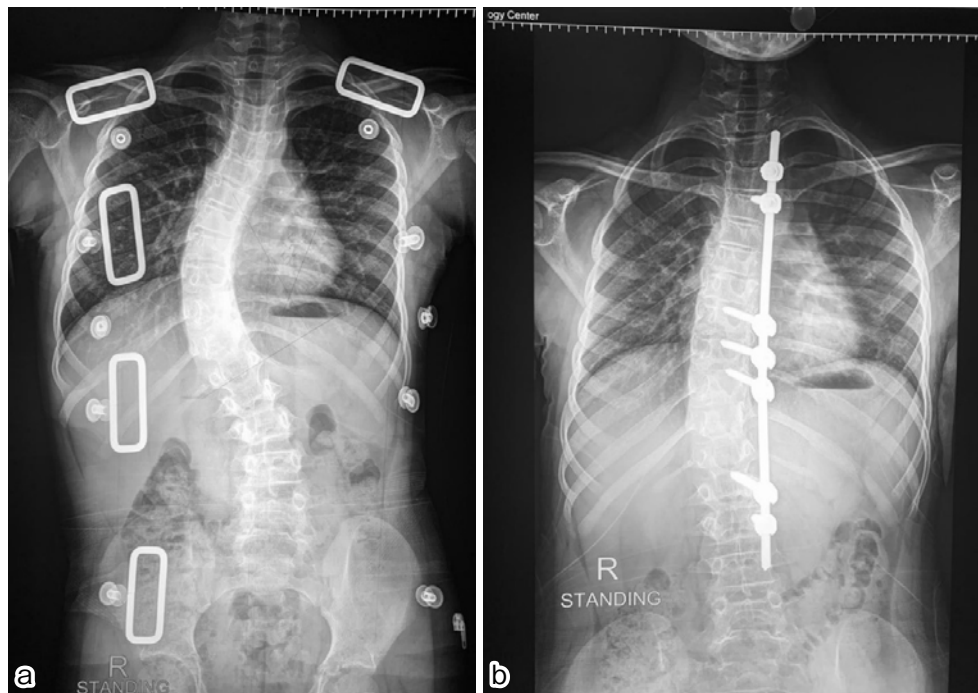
Figure 2 shows (a) preoperative and (b) postoperative X-rays using the single rod technique.
